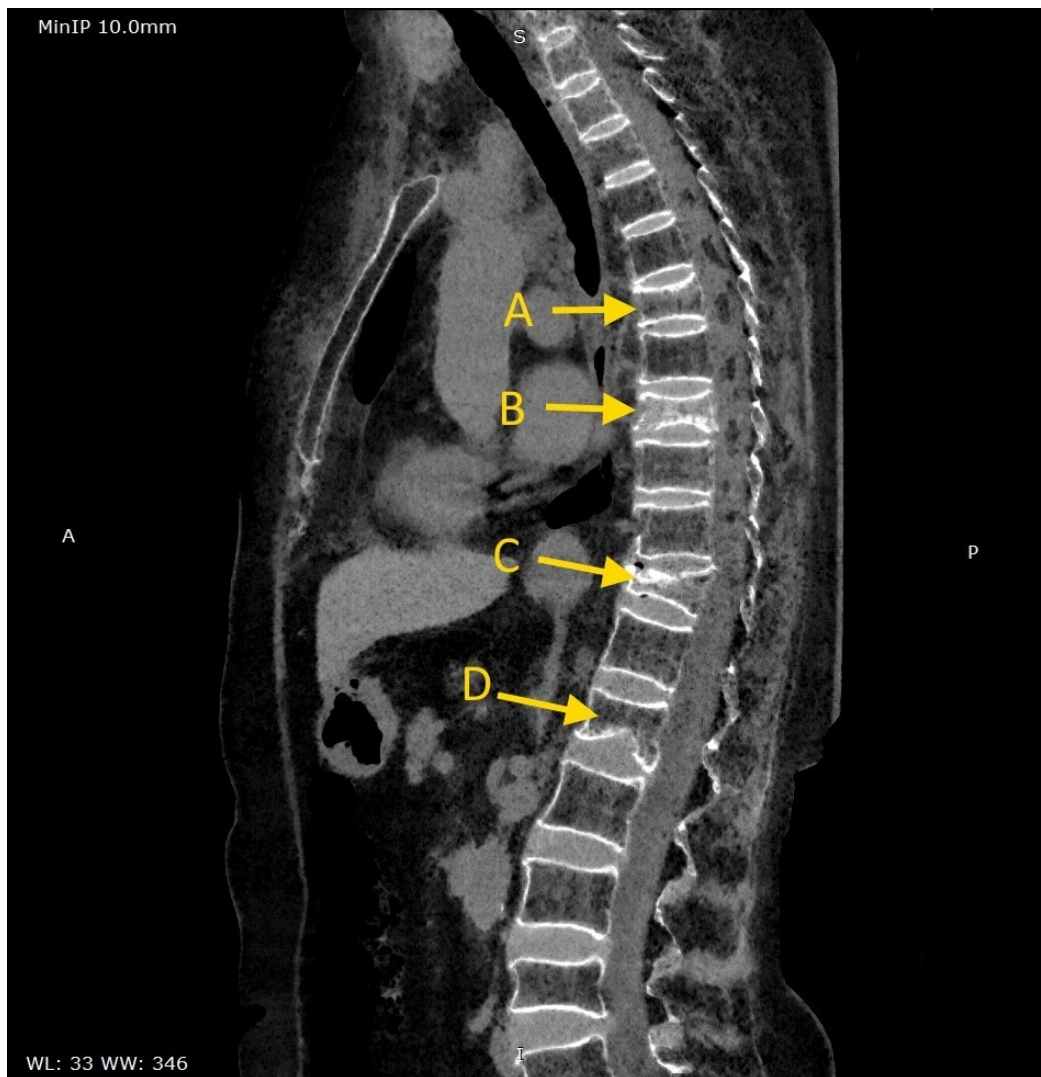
The CT scan (image with sagittal reconstruction in maximum intensity projection) detects deformation of the vertebrae resulting from compression fracture (yellow arrow):
